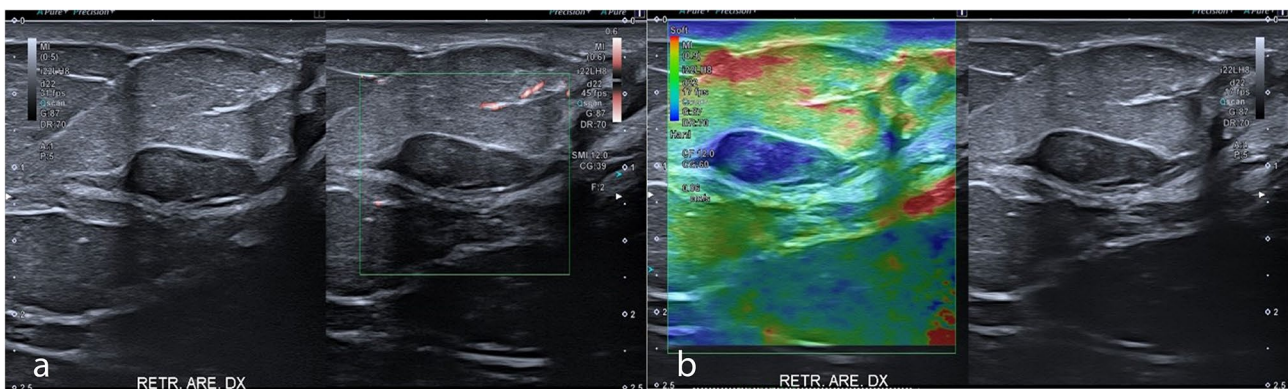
a US show with the color Doppler internal vascularity, important to aid in the therapy management. b The strain elastography show a homogenic stiffness or a mosaic pattern
